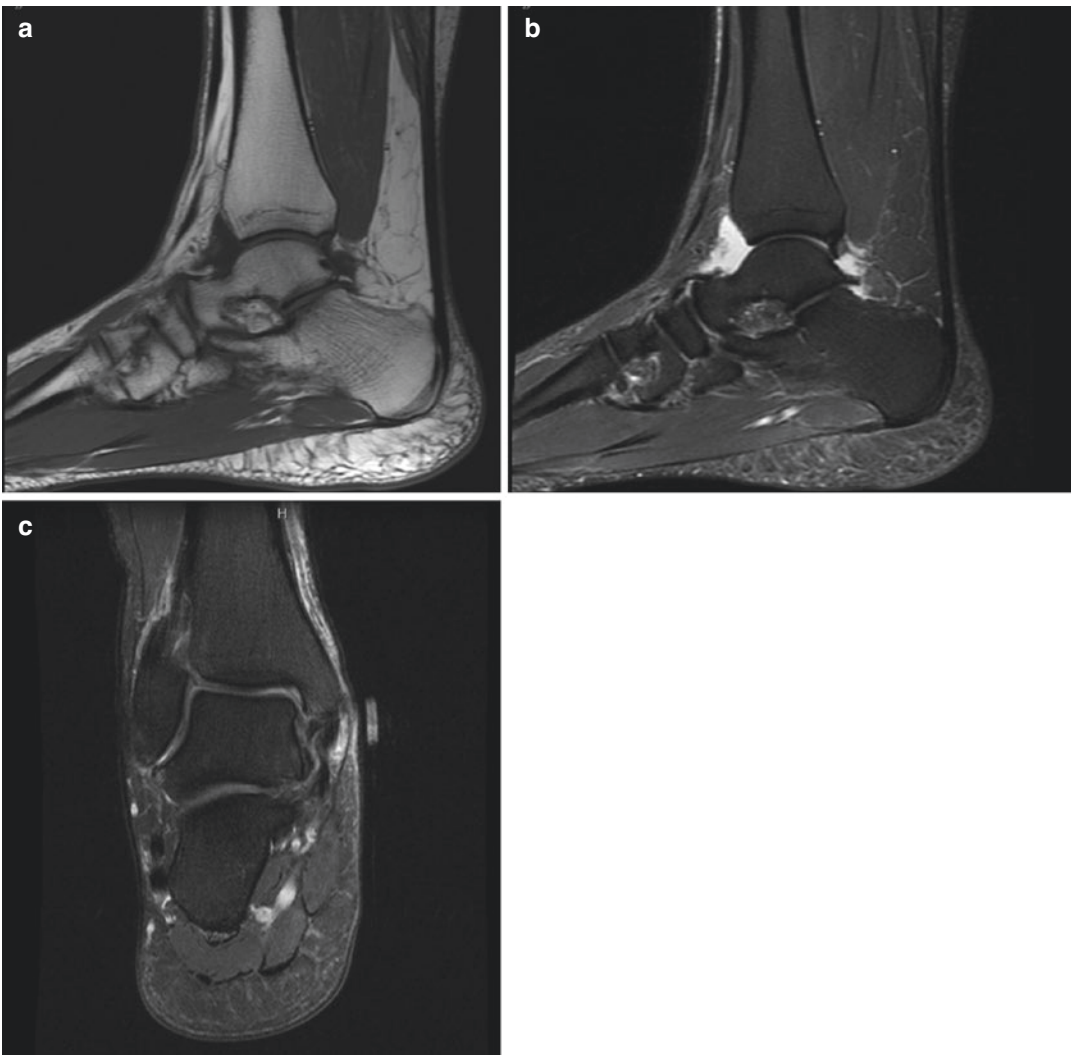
Different MRI sequences highlight unique elements of patient anatomy and pathology. (a) T1 MRI image sagittal view of the ankle. (b) STIR MRI image sagittal view of the ankle. (c) PD MRI image coronal view of the ankle
